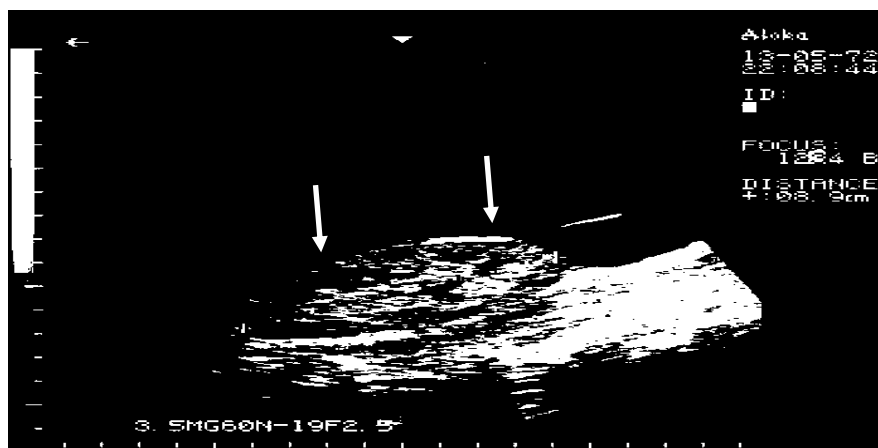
Ultrasonogram of the kidney in chronic glomerulonephritis and chronic renal failure. The kidney is reduced in size, echogenicity of the parenchyma increased. The free fluid in the abdominal cavity is determined.
